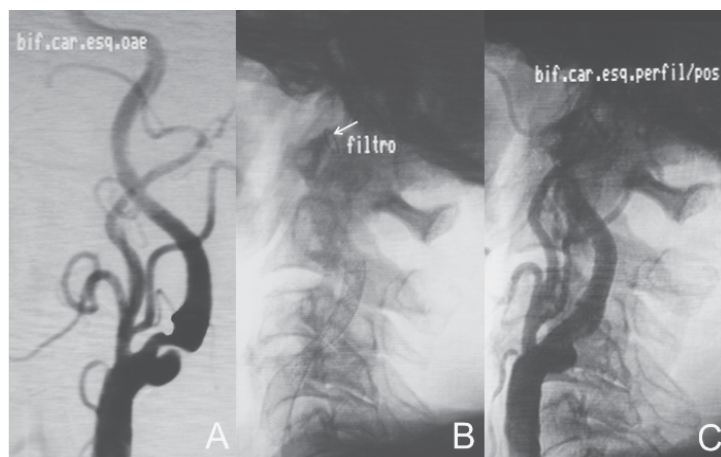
Patient number 2, 70 years old, male with diabetes, hypertension and coronary ischemia, displayed transient ischemic attack. . DWI exam after CAS (not shown) did not reveal microusemboli. Angiography showed stenosis of 70% (A) in the left carotid artery with additional imaging (ulcer). EPI® open carotid filter (arrow) and Wallstent (7 x 40 mm) self-expandable stent (B). Control angiography after CAS (C)
